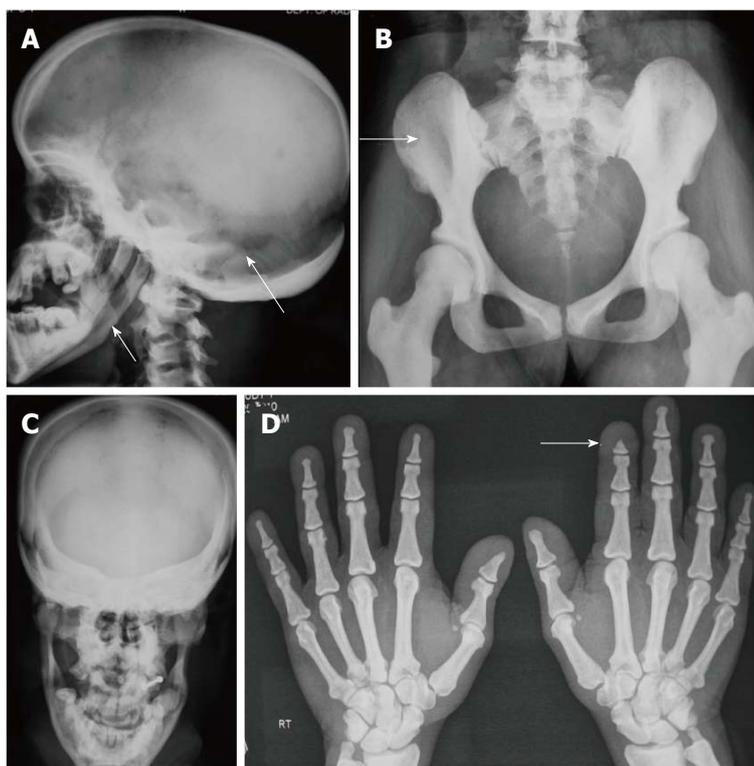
Pyknodysostosis. Radiographs of skull (A, C) show hypoplastic mandible, open sutures and increased bone density (arrows, A). Increased bone density also noted in pelvis (B) and hands (D). Also note acroosteolysis (arrow, D).
